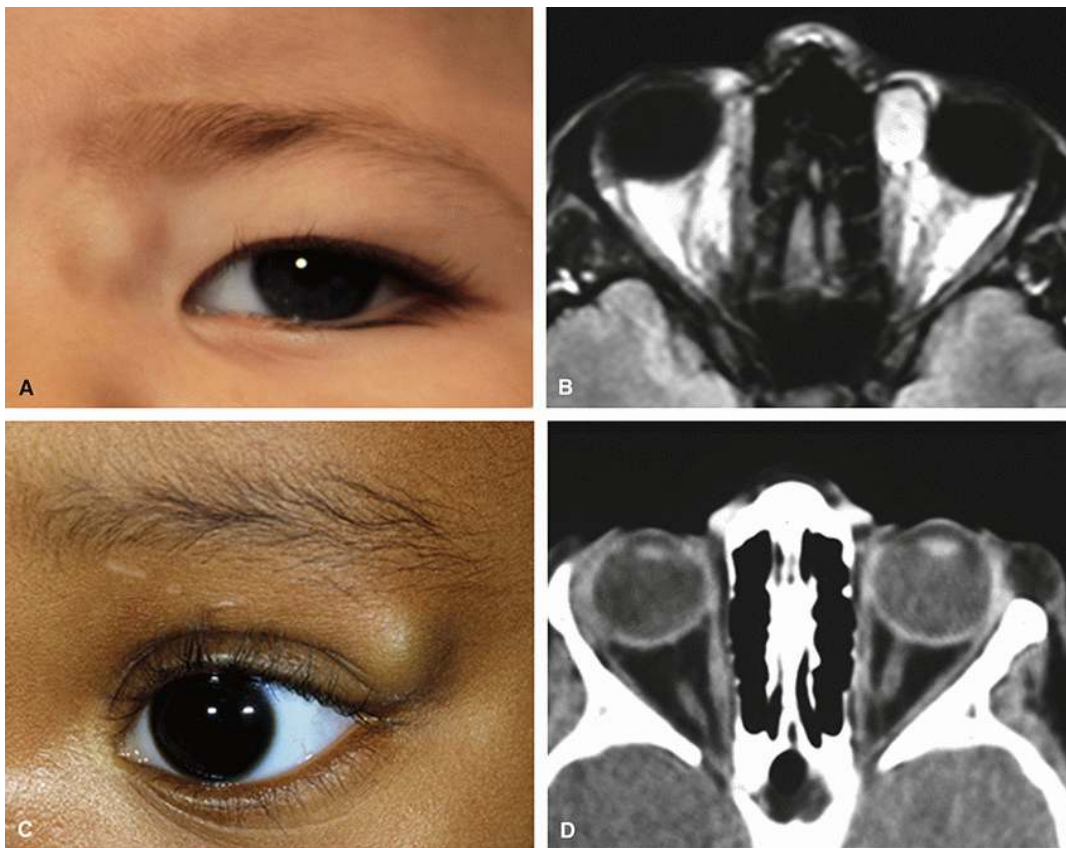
Major locations of periorbital dermoid cysts. A, Superomedial dermoid. B, Axial magnetic resonance scan of a medial orbital and eyelid dermoid cyst. C, Superotemporal dermoid cyst. D, Axial CT scan of a superotemporal dermoid cyst.
